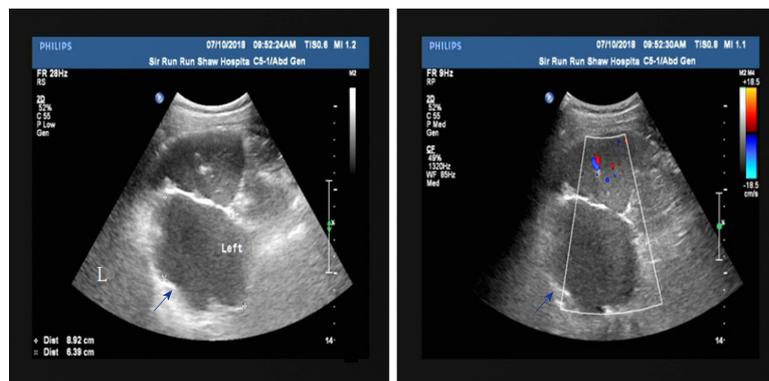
Ultrasound images of the gastric duplication cyst. A large cystic focus (blue arrow) was visible in the space between the spleen, stomach, and left kidney, with no vascularization on Doppler.
